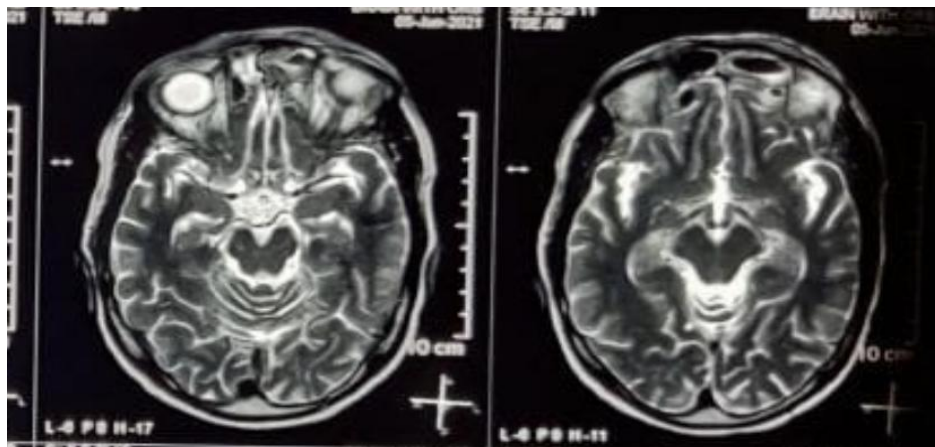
CE-MRI showing Left periorbital involvement
